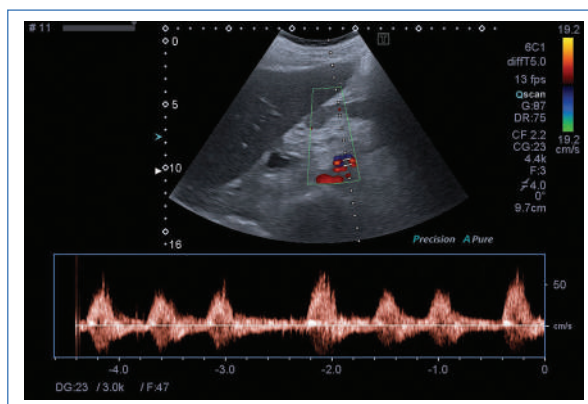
Renal doppler as part of VeXus protocol.
